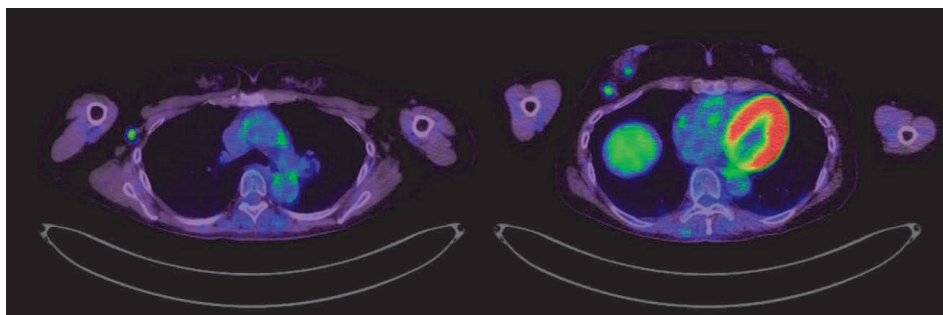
A screening PET-CT scan showed abnormal FDG accumulation in the right breast (SUV max 2.868) and one right axillary lymph node (SUV max 4.131).
